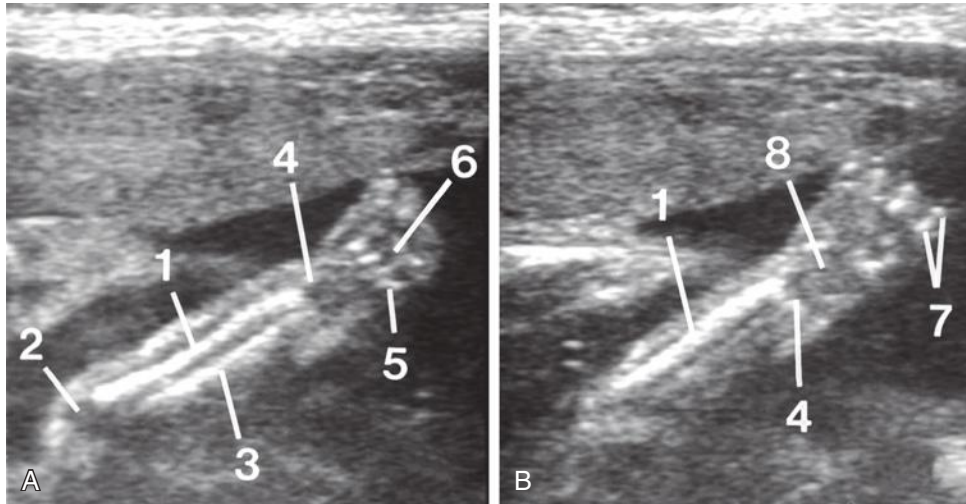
A and B, Coronal sonograms of the forearm and wrist. 1, ulnar diaphysis; 2, olecranon in cartilage; 3, radial diaphysis; 4, distal ulnar epiphysis; 5, metacarpal diaphysis; 6, distal metacarpal epiphysis; 7, phalangeal ossification centers; 8, carpal arch seen as a conglomerate cartilage.
